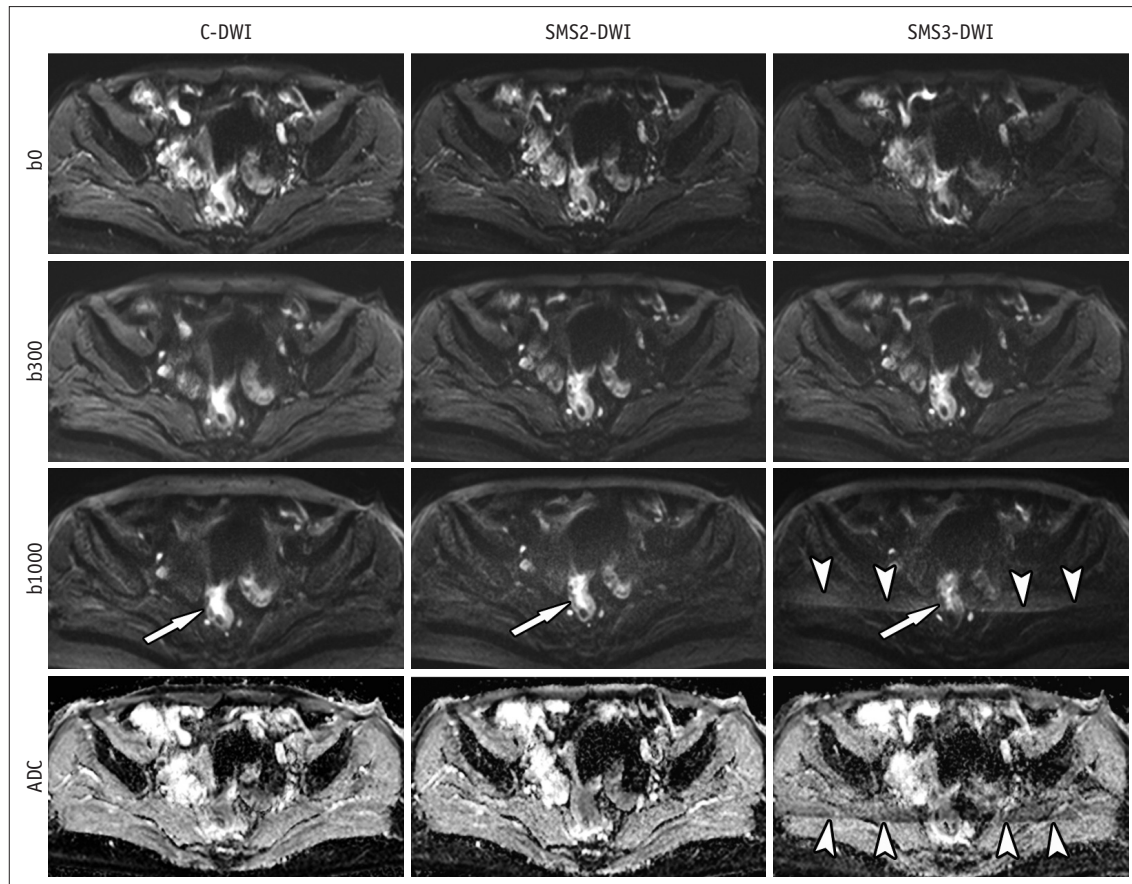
C-DWI and SMS2-DWI and SMS3-DWI in 66-year-old female with rectal cancer. Image set consists of b0, b300, b1000, and ADC map. Image quality and lesion conspicuity for rectal cancer (arrows) in SMS2-DWI are not significantly different from those in C-DWI. However, SMS3-DWI shows decreased lesion conspicuity (arrow) and significant aliasing artifacts (arrowheads) in comparison with C-DWI and SMS2-DWI. Overall image quality scores were 3, 4, and 2 for C-DWI, SMS2-DWI, and SMS3-DWI by both readers. b0, b = 0 s/mm²; b300, b = 300 s/mm²; b1000, b = 1000 s/mm².
